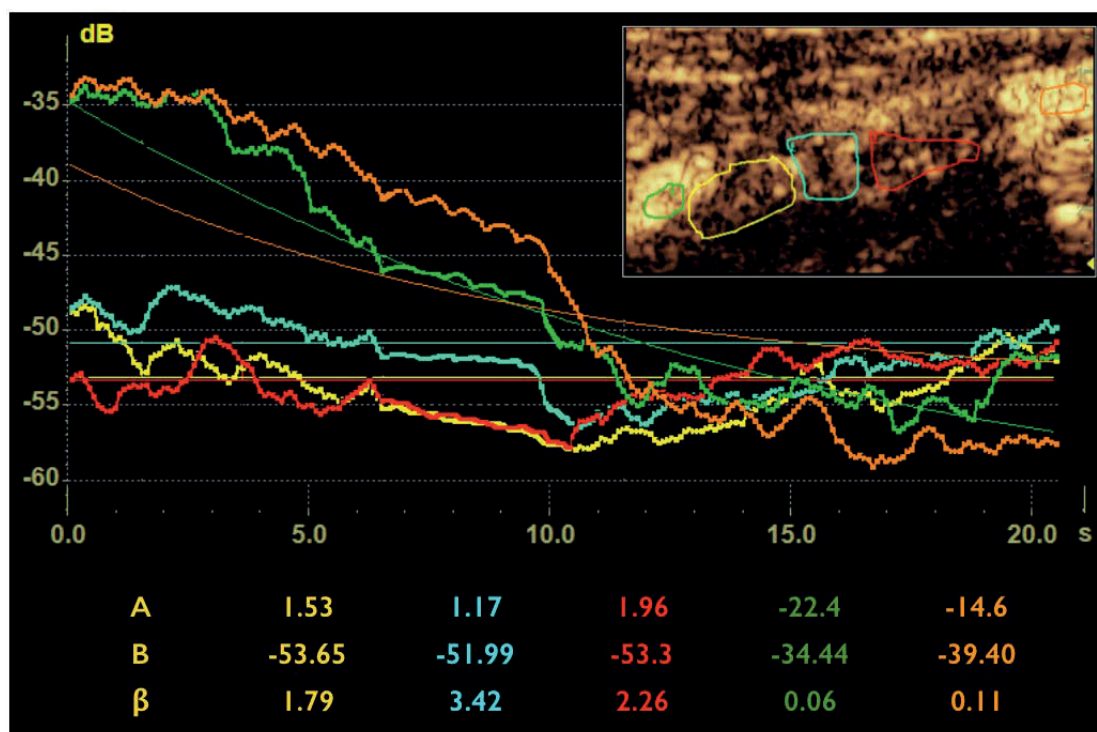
An example of a TIC analysis results in patient M. with symptomatic hemodynamically significant stenosis of the right internal CA. Note: at the top right is a scan of a longitudinal section of the internal carotid artery during contrast-enhanced ultrasound. Five areas for evaluating the acoustic intensity were allocated. The orange and green areas correspond to the proximal and distal parts of the internal CA. The red, turquoise and yellow areas correspond to the proximal, middle and distal parts of the atherosclerotic plaque. The center presents graphs of the dynamics of the acoustic intensity in the studied areas for 20 seconds after flash. The curve colors correspond to the colors of the areas shown on the scan. Thin curves is modeling the exponential dependence of the acoustic intensity on the estimated areas of the same color. Below are the coefficients of the equation for each of the 5 areas.
